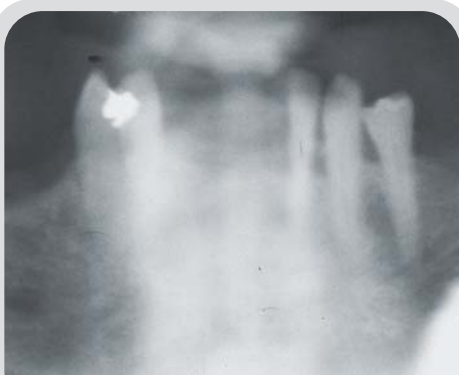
Panoramic radiograph taken prior to tooth extraction and initiation of the IOL procedure.
